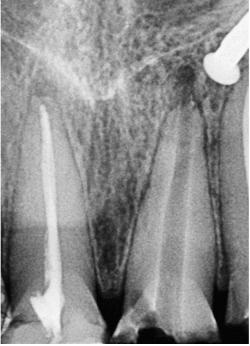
Radiographic image of removal of overextended GP
